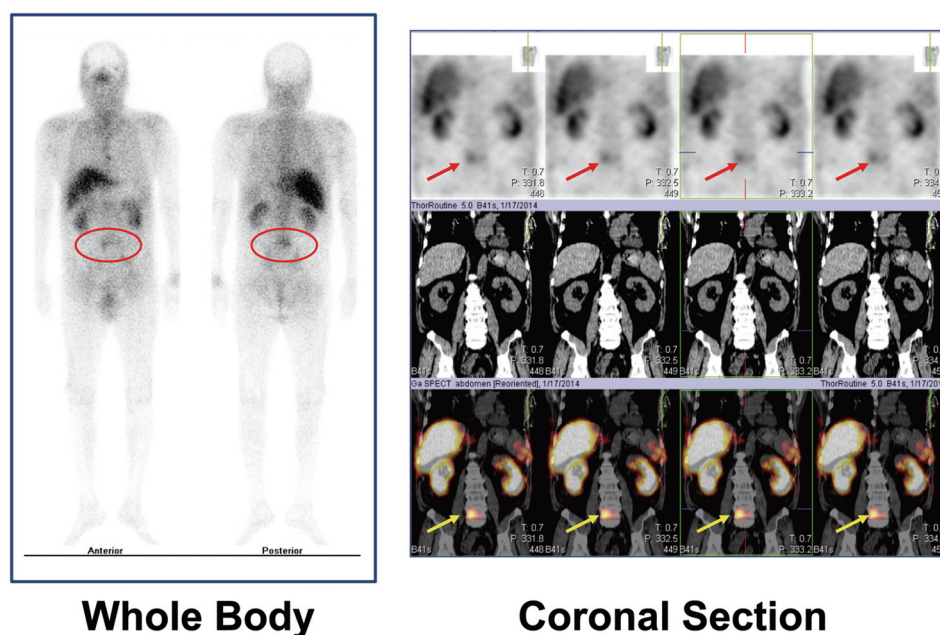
Representative case of infection after HTx: vertebral osteomyelitis detected by ^{67}Ga scintigraphy
